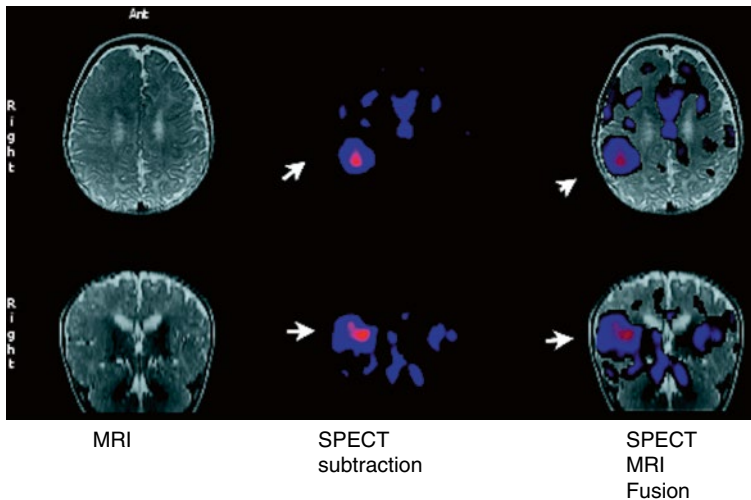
Six-month-old boy with one to two spells/day since birth. More recently he developed five to six seizures in a row over a 2–5-min period, up to five to seven times per day. The electroencephalograph (EEG) was quite active during sleep. The MRI revealed an abnormal gyral pattern in the right frontal and parasyllian regions suggestive of “neuronal migration disorder.” An interictal ^{18}F -FDG PET revealed generally decreased tracer uptake
